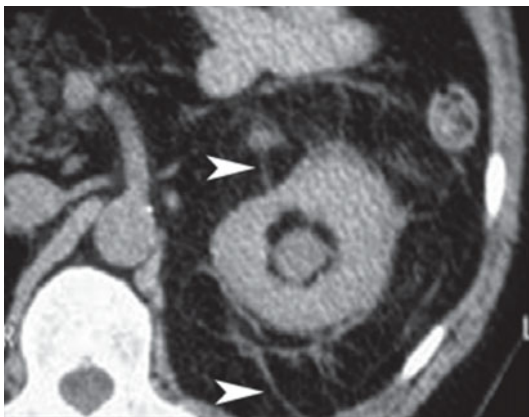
Computed tomography. Axial scan. Perirenal space. In this post-pyelonephritis patient bridging septa are visible connecting the capsule and the fascia (*arrowheads*)
